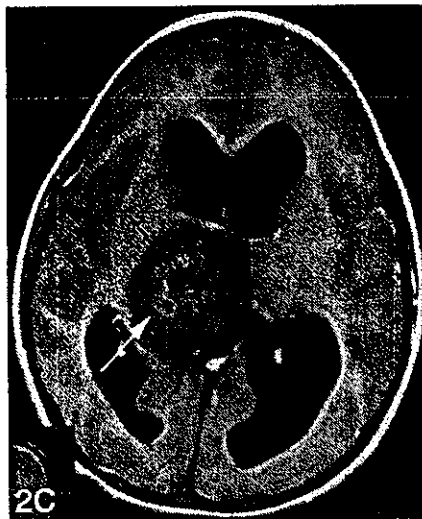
Noncontrast CT scan shows a low-attenuation mass in the right thalamus. Marked calcifications are seen in the center of the mass lesion (arrow).
